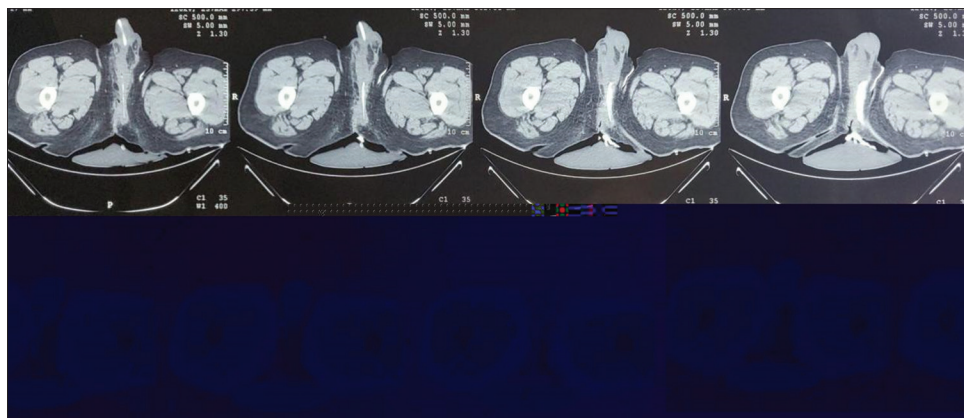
Computed tomography urethrography
